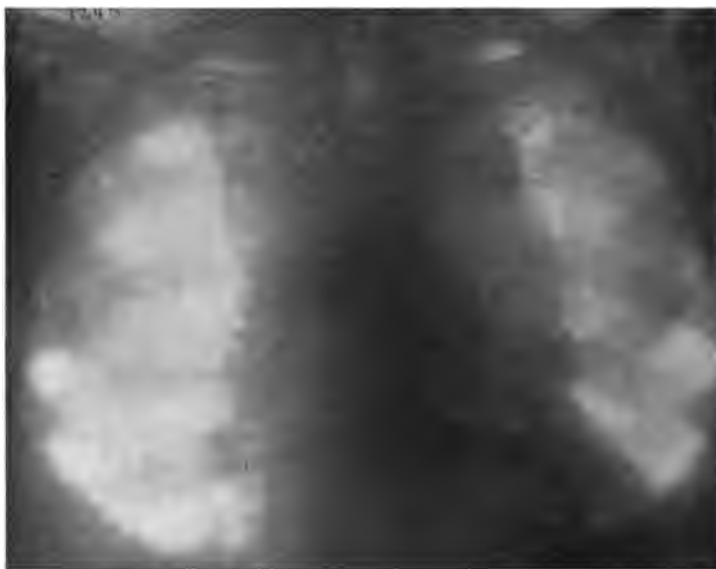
Radiograph of a mediastinal neoplasm. Anterior aspect, showing abnormal extension and density of the mediastinal shadow, with dislocation of the heart. (Plate by Dr. W. F. Manges.)
